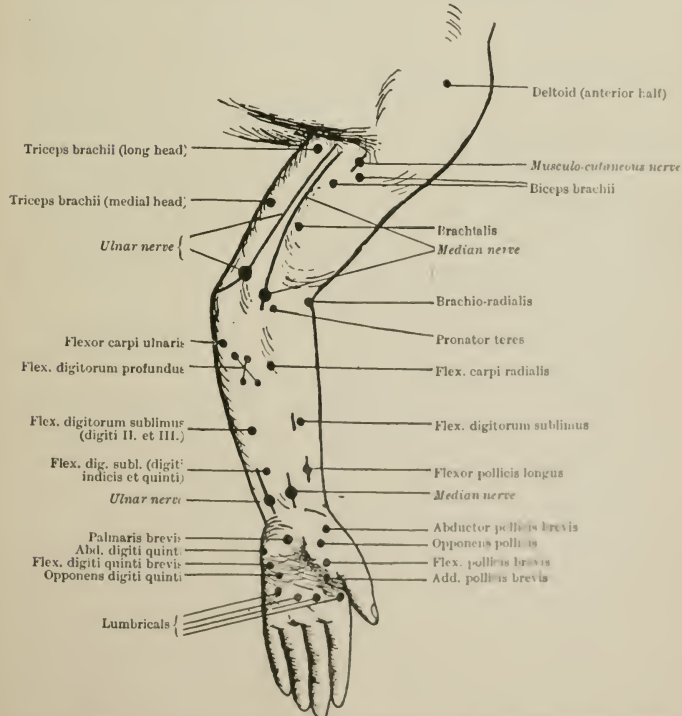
MOTOR POINTS OF THE UPPER EXTREMITY—ANTERIOR ASPECT (after Erb).
